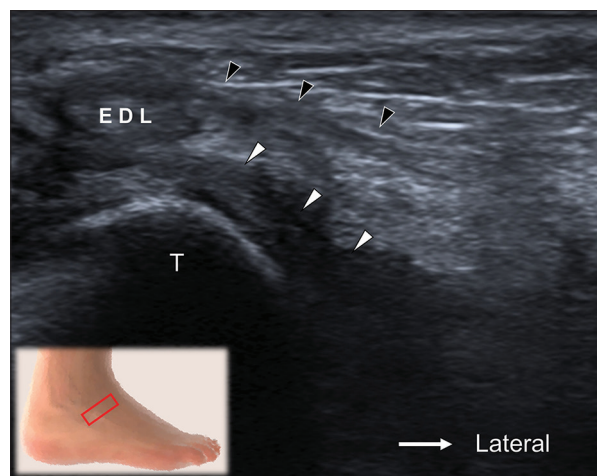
Ultrasound imaging of the left inferolateral ankle. Black arrowheads: Lateral root of the inferior extensor retinaculum, black arrowheads: Intermediate root of the inferior extensor retinaculum, white arrowheads: Medial root of the inferior extensor retinaculum, T: talus, EDL: Extensor digitorum longus tendon
